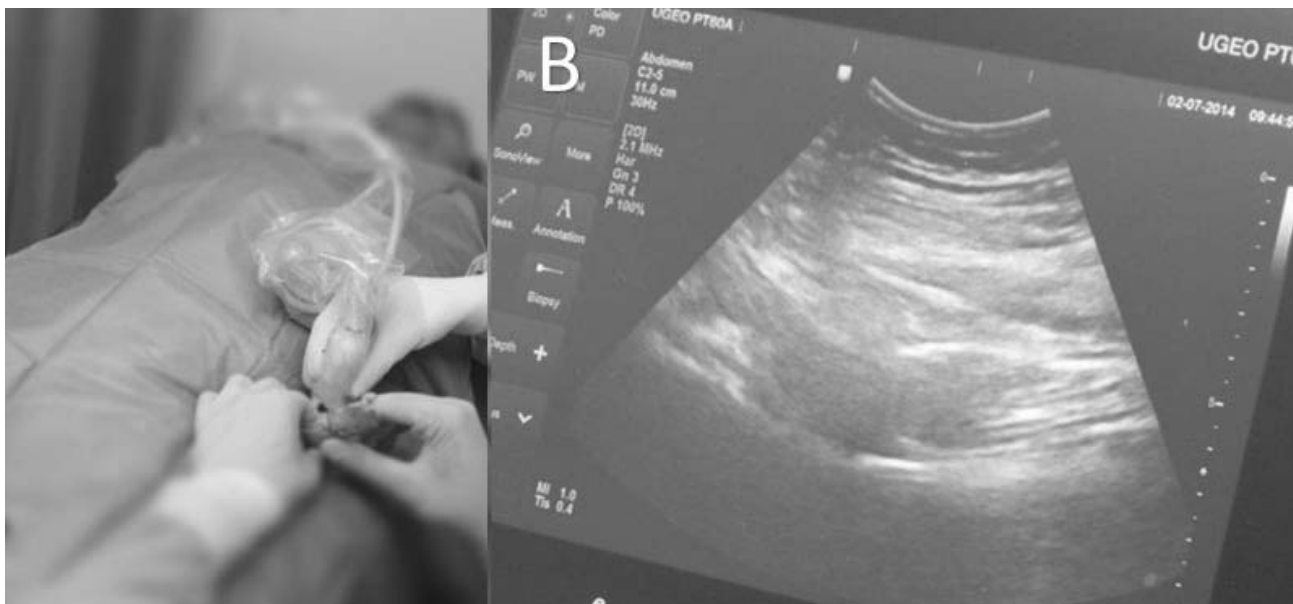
a): Application of intra-articular injection of HA in the hip joint under guidance of ultrasound; b): The accuracy of the injection was confirmed by direct visualization under ultrasound guidance.
